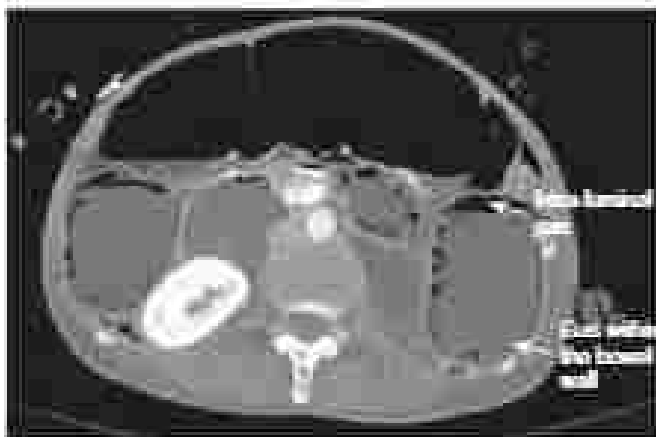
Cravely locates intraluminal air superiorly, however, gas within the bowel wall (PW) will completely surround the loop of bowel (Fig. 1). This can make it easier for the surgeon to identify PI on a CT scan.
